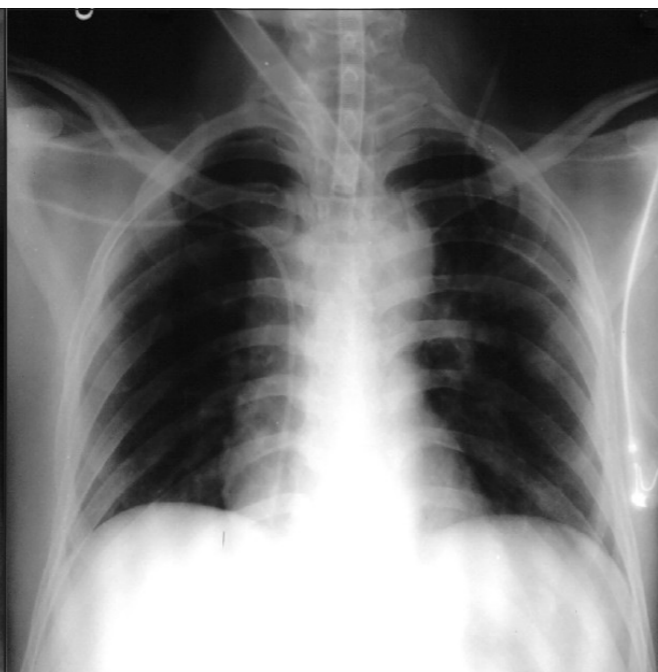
Chest X-ray with catheter in situ
